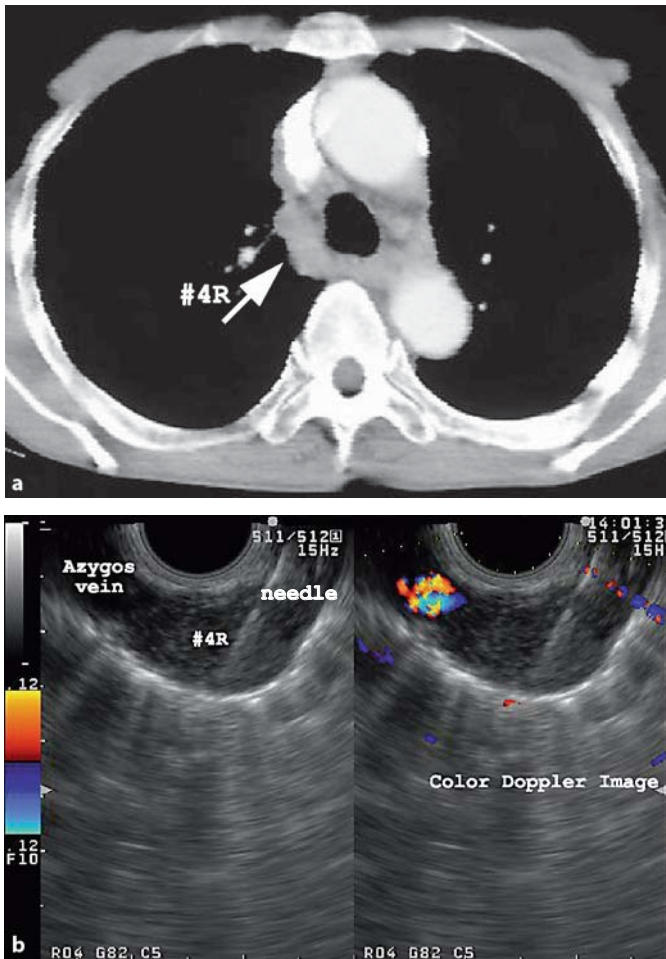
A case of NSCLC with lymph node swelling at level 4R. a The contrast-enhanced CT image shows an enlarged lymph node just above the azygos arch (arrow). b EUS-FNA was performed on the lymph node. The left image is a fundamental image and the right image is an image with color Doppler function.
